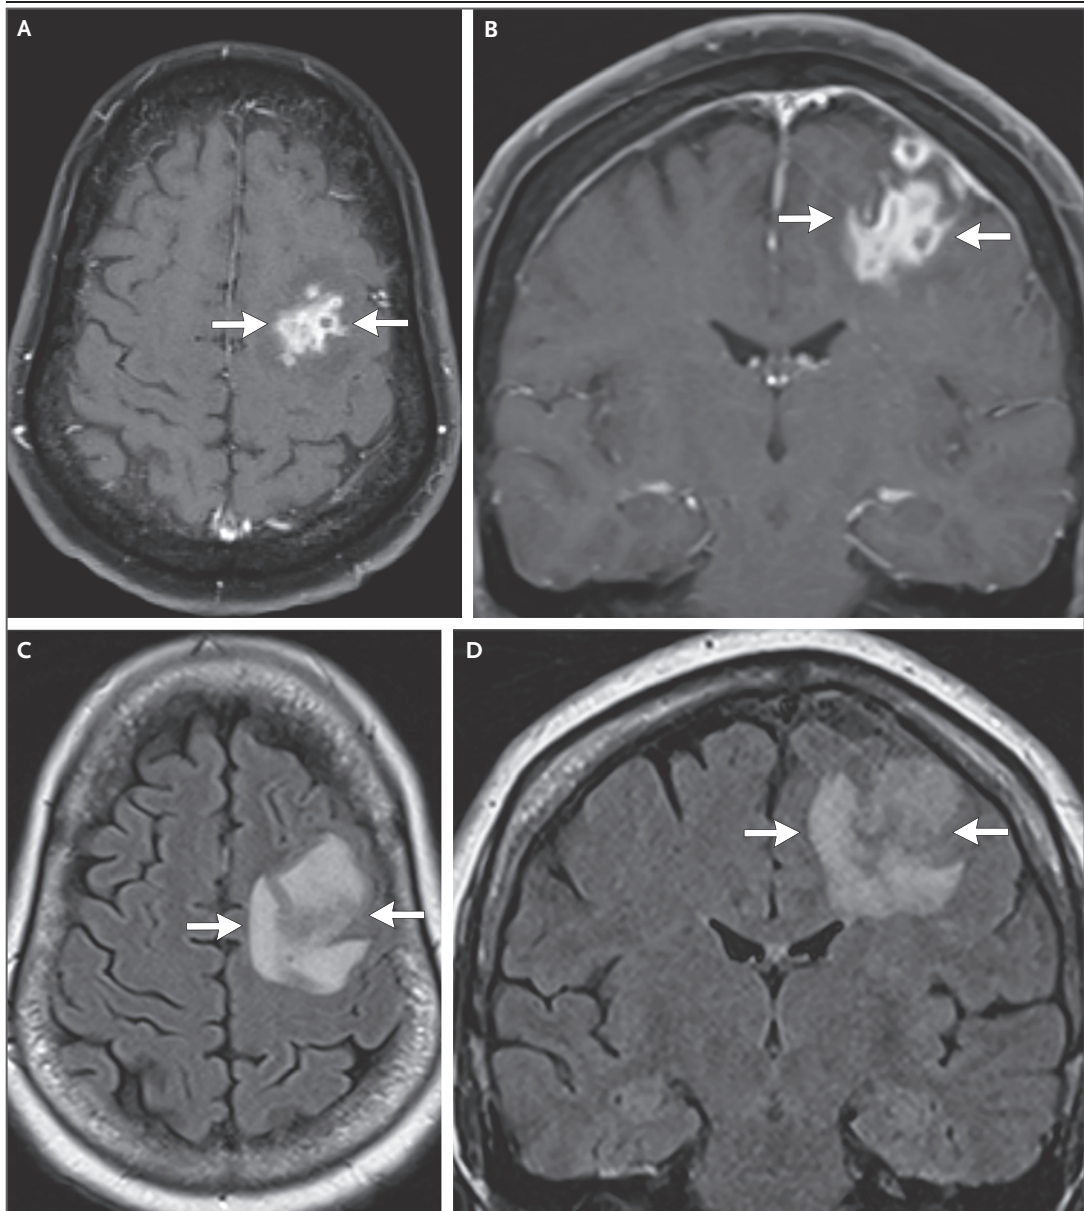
MRI of the Head Obtained on Hospital Day 2.
